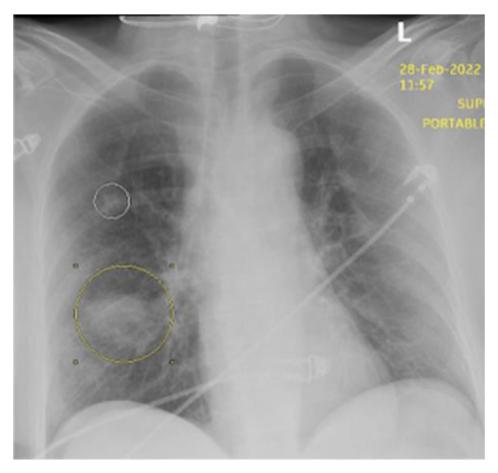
Chest x-ray showed a mass-like opacity in the right perihilar region. (Yellow circle), an irregular nodular opacity in the right upper lobe (white circle) and increased interstitial markings bilaterally.
